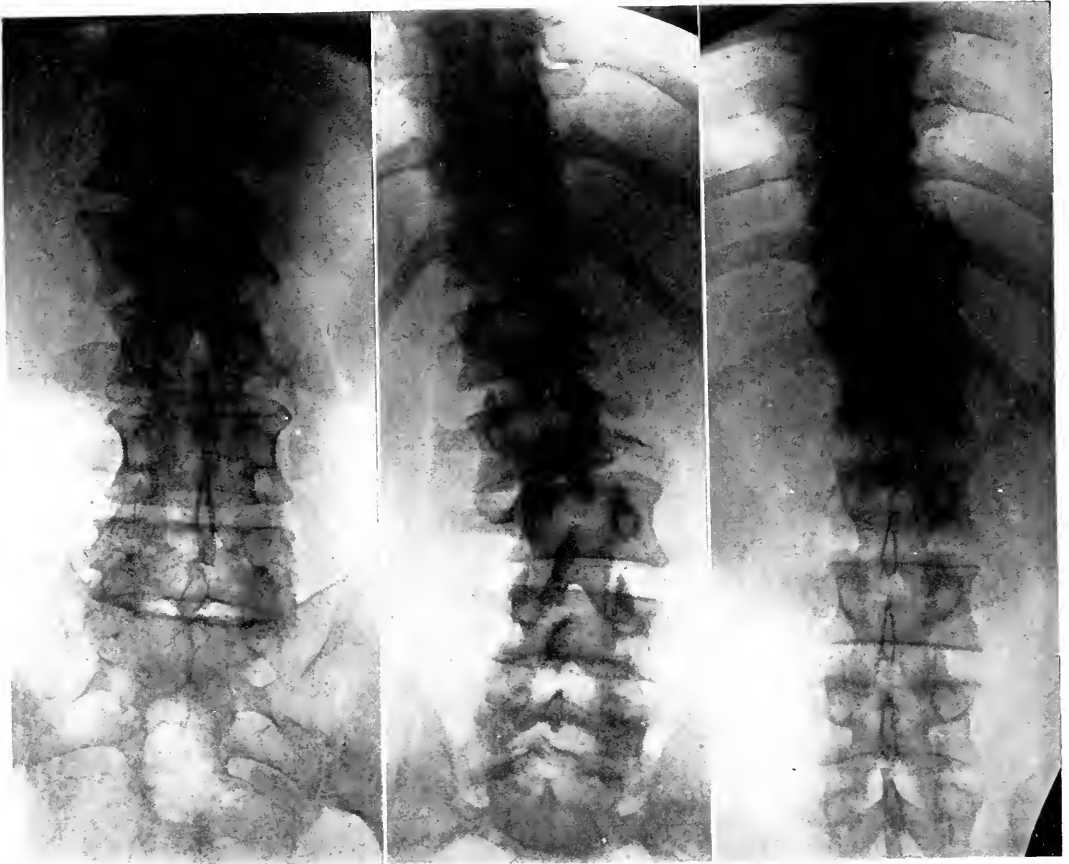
A FEW FRACTURED SPINES SHOWING LARGE SCOPE OF EXPLORATION WITHOUT SACRIFICE OF RADIOGRAPHIC QUALITY.
